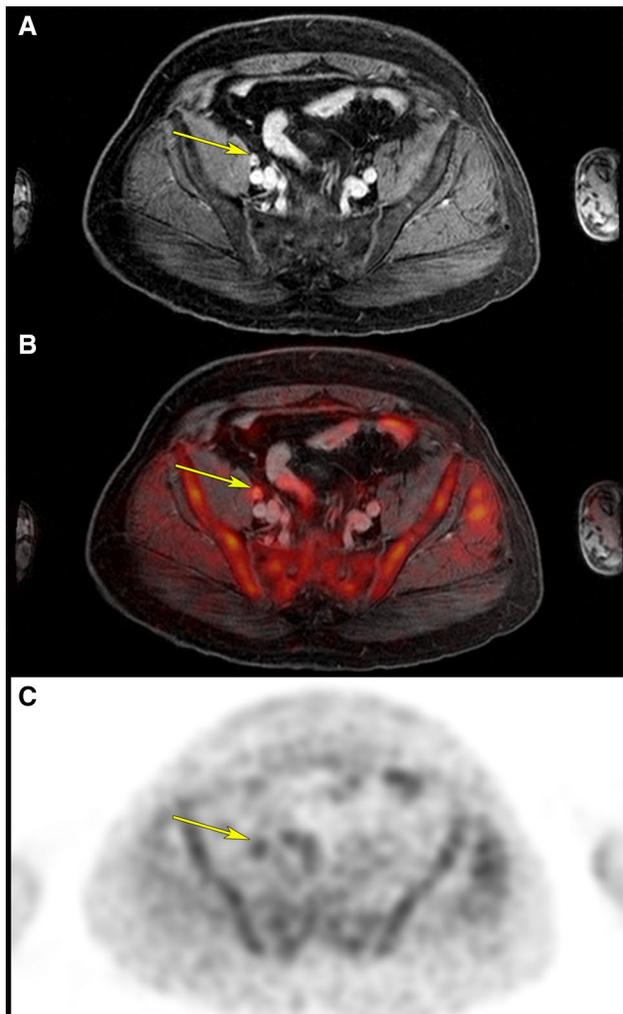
FCH PET/MRI images showing a FCH positive and mpMRI negative pelvic lymph node recurrence in a 71-year-old man with a pT3a pN0 R0 Gleason 3+4 disease in a biochemical recurrence (PSA 0.6 ng/ml) after radical prostatectomy. a Right external iliac nodal recurrence with non-specific findings on axial VISTA sequences, b with positive FCH uptake on fused PET/MRI, c and native PET images. The patient is in complete biochemical remission 31 months after salvage whole pelvis radiotherapy
